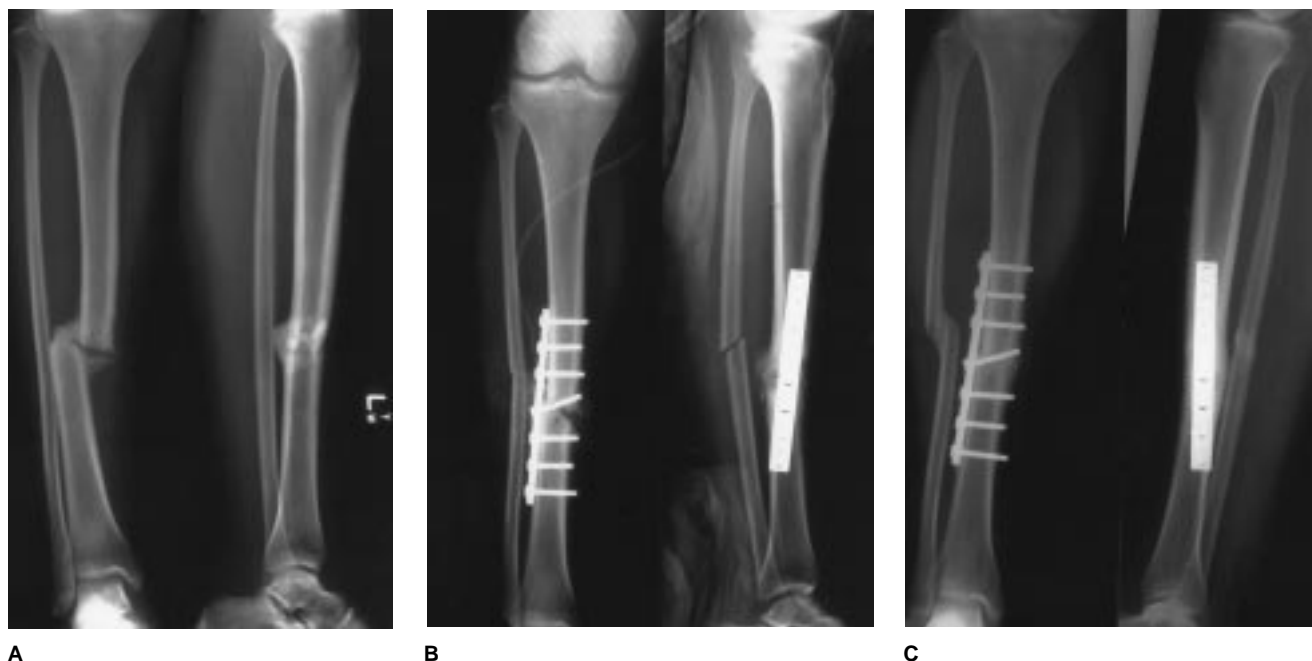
A, Fourteen weeks after multiple blunt trauma, this closed, displaced, angulated tibial shaft fracture remained painful and nonunited. B, Open reduction and internal fixation with plate osteosynthesis was performed without bone graft. A lag screw was used to increase interfragmental compression. C, Radiographs obtained at 15 months show uneventful fracture healing.
